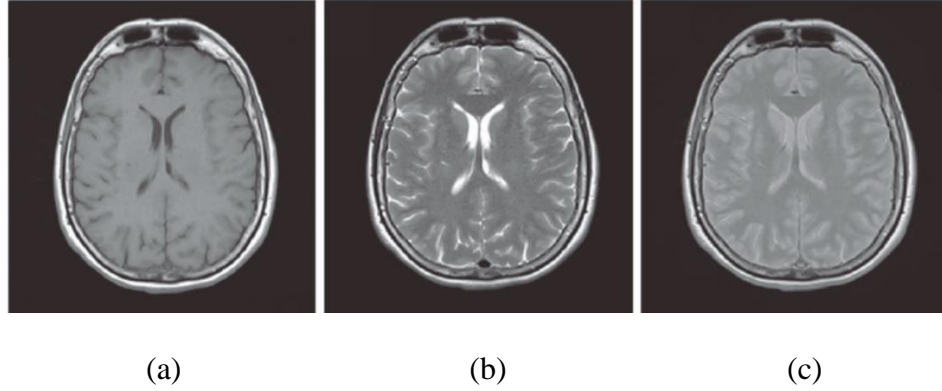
Examples of T1, T2 and proton density weighted images. Part (a) shows a T1-weighted image, (b) T2-weighted image, (c) Proton-density-weighted image. The figure was adapted from Plewes and Kucharczyk (Plewes & Kucharczyk, 2012).
